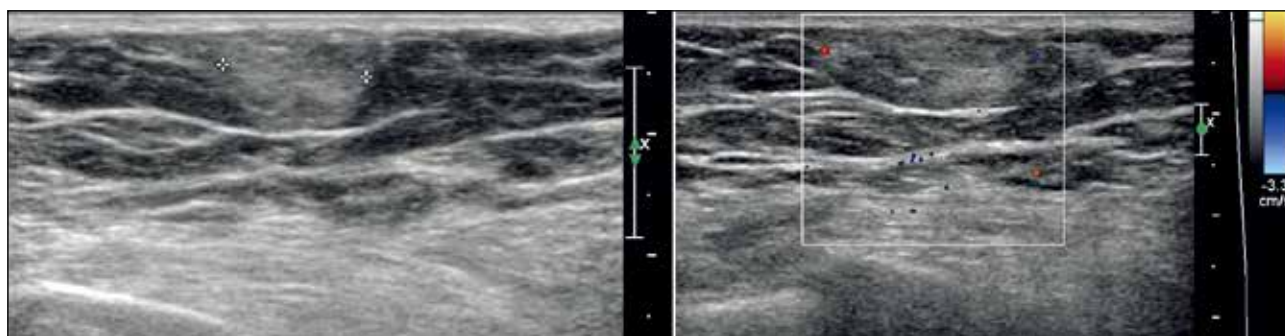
A 69-year-old woman presented with palpable left breast mass. Ultrasonogram showing a predominantly echogenic subcutaneous lesion, similar to that expected for a lipoma. However, mild peripheral vascularity is present, thus biopsy was performed and confirmed the lesion to be an angioliipoma.
